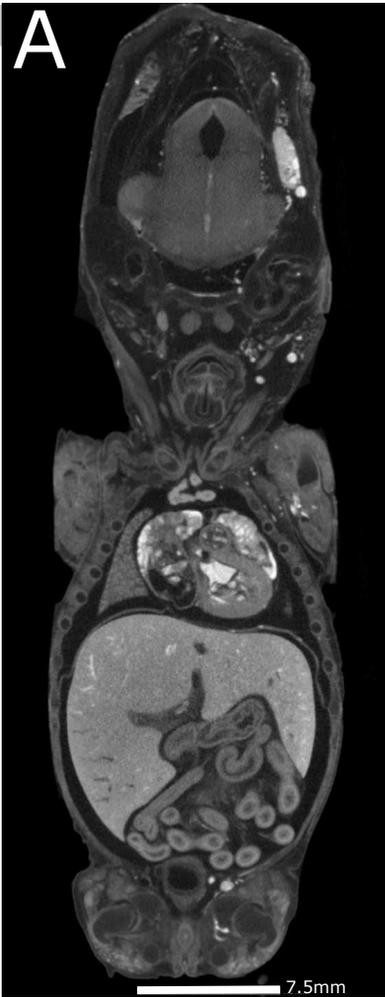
An apparent miss from case 4 at micro CT examination was a sacral NTD, which was easily detected at external examination (star), but overlooked on the micro CT data (B).
